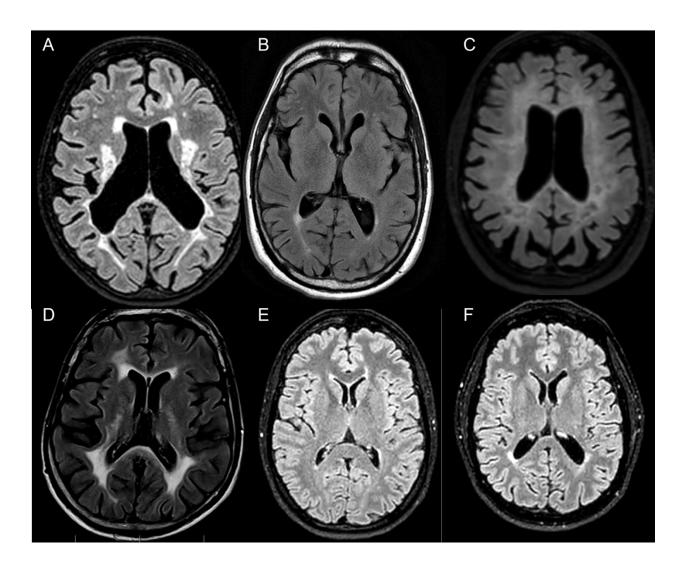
Selected axial T2-weighted MR images of the 6 participants with confirmed or suspected disease-causing variants.
